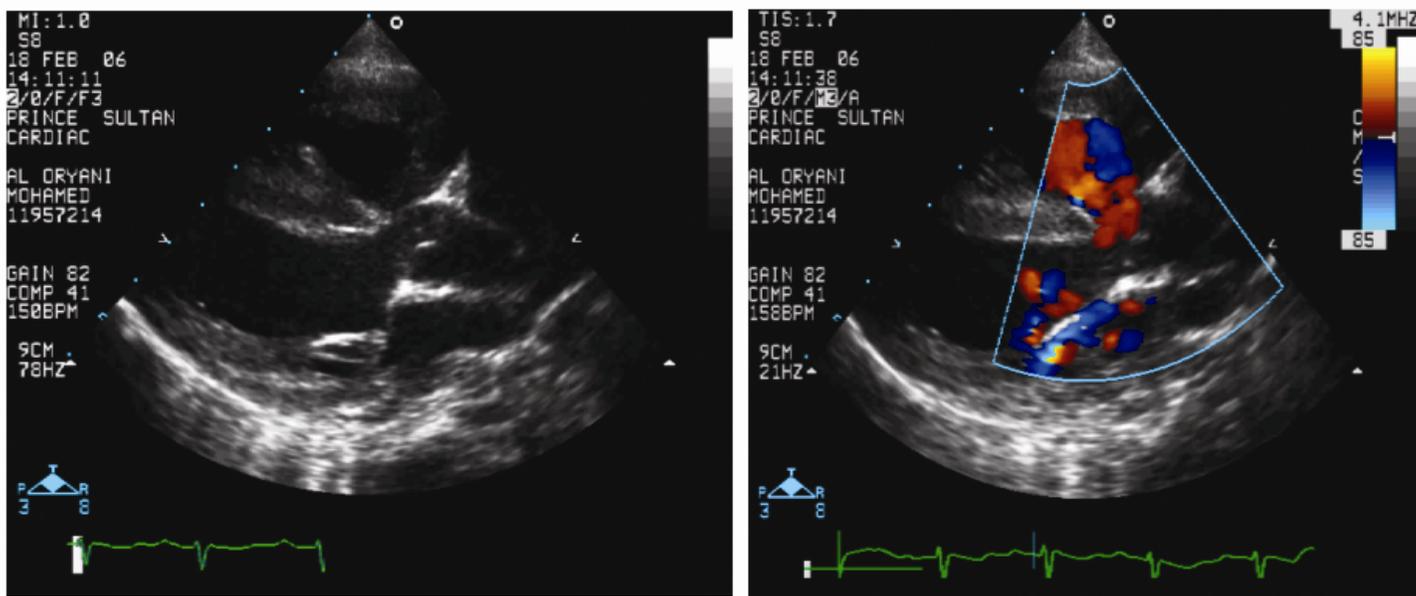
Echocardiography of the patient showed malaligned VSD & overriding of aorta.
